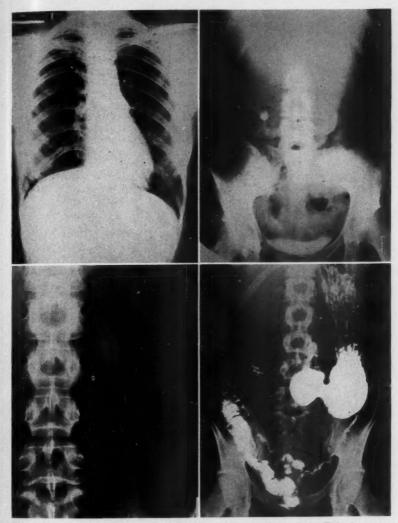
Roentgenologic Studies In Right Adrenal Tumor. Upper Left: This chest roent-genogram shows mild elevation of the right diaphragm with moderate displacement of the heart to the left. Upper Right: The intravenous pyelogram shows downward displacement of the right kidney. Lower Left: The cholecystogram reveals displacement of the gallbladder into the left upper quadrant. Lower Right: The gastrointestinal series presents some downward displacement of the pylorus and duodenum and, in addition, the lateral roentgenogram presented some anterior displacement of the body of the stomach.
